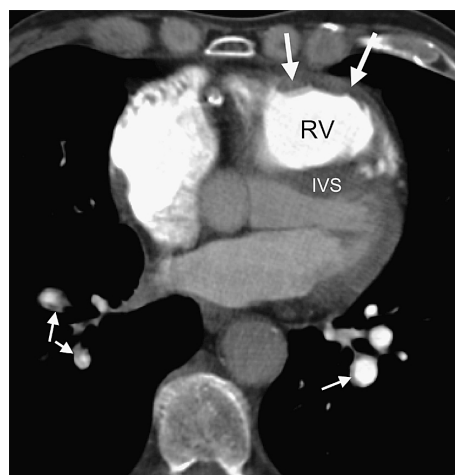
Multidetector computed tomography in chronic embolic pulmonary arterial hypertension; thin mural thrombus (arrows) in the segmental arteries of the lower lobes. IVS = interventricular septum; RV = right ventricular outflow tract with hypertrophic wall (thick arrows).
